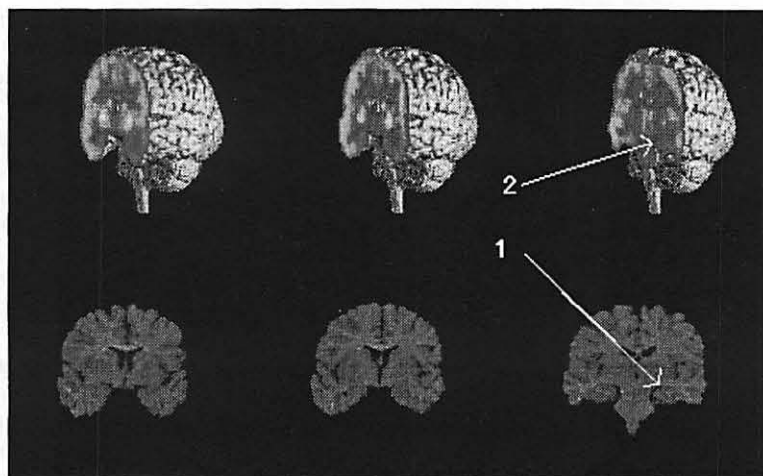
Visualization of a mesial temporal epilepsy case. Top: PET viewed on the cut surface of registered 3D MRI volume. Arrow 2 indicates hypometabolism in the left temporal lobe region. Bottom: The corresponding MRI coronal slice shows subtle structural atrophy of hippocampus within the left mesial temporal lobe (arrow 1).
